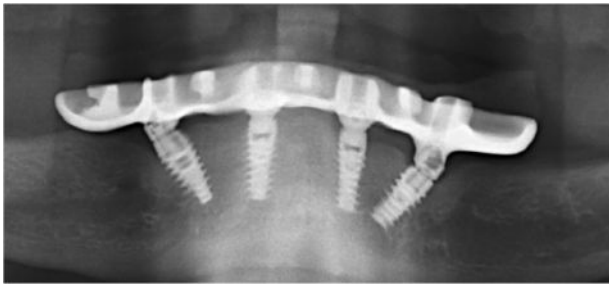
Radiographic view depicting fractured multiunit screws on anterior implants.
